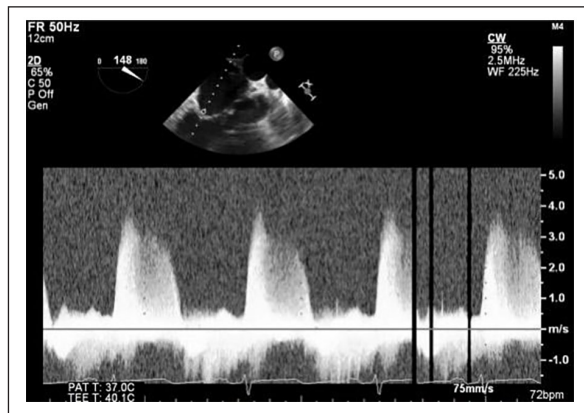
Intraoperative transesophageal echocardiography (TEE) with pre-surgical continuous wave (CW) Doppler profile of the mitral regurgitation jet.
